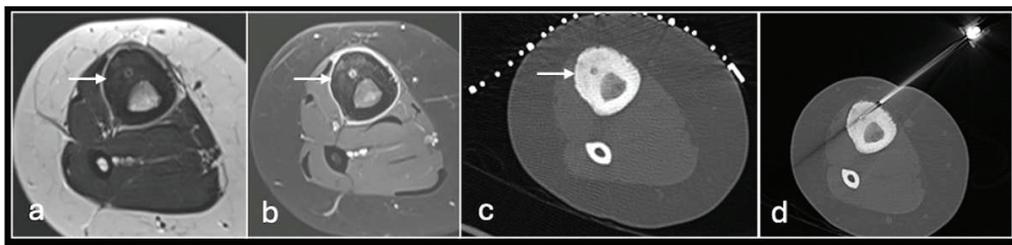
Axial T1 (a), STIR (b), CT (c) showing osteoid osteoma of tibia (arrow) treated with radiofrequency ablation (d).
